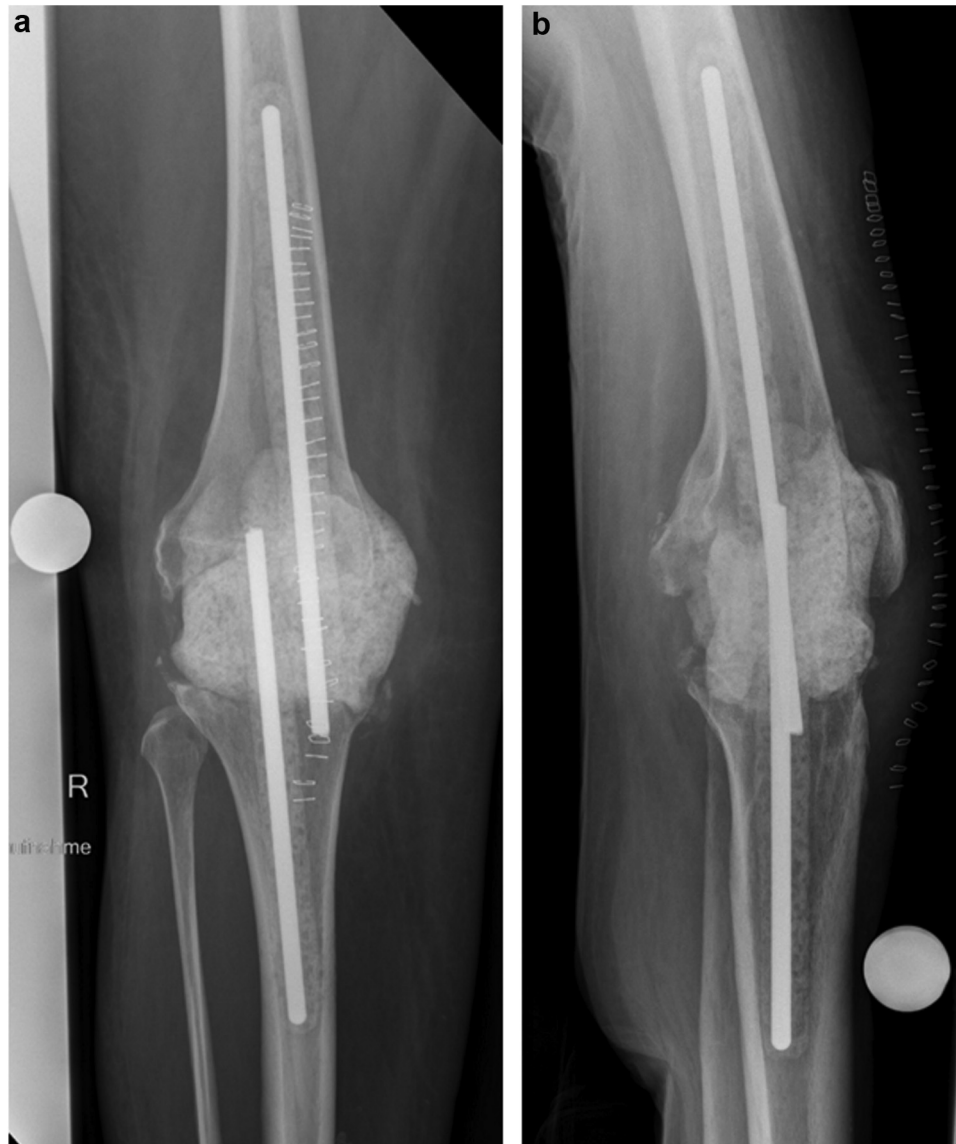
Anteroposterior (a) and lateral (b) radiographs of the spacer impregnated with gentamicin, clindamycin, and voriconazole.
